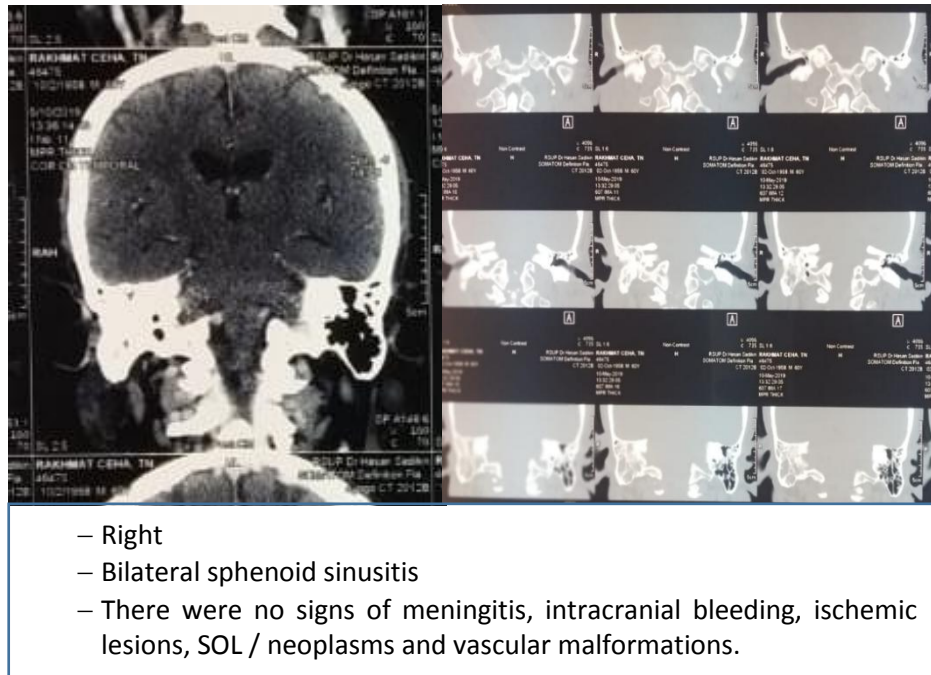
Temporal CT Scan
